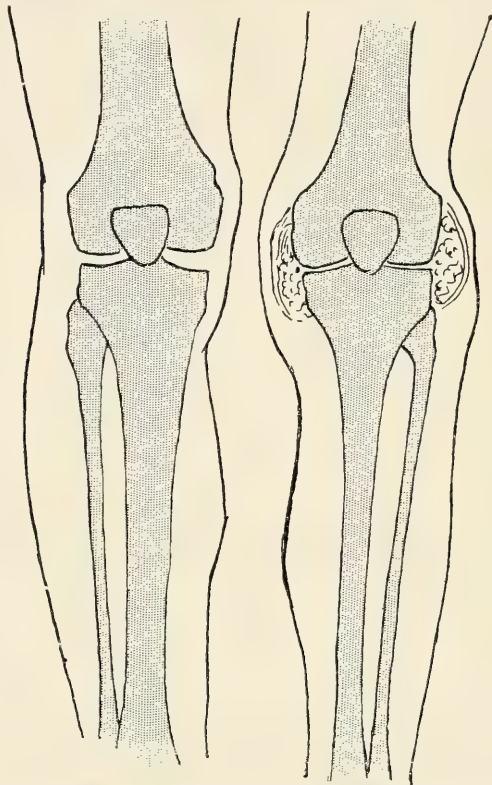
White swelling of the knee (after a radiograph). Atrophy of the skeleton on the affected side; increase in volume of the knee, proceeding from the distension of the synovial cavity by fungous masses. — Compare with fig. 1030. Other elements of diagnosis with osteo-myelitis: tuberculosis generally involves the articular extremities; osteo-myelitis nearly always the diaphysis. The onset is insidious in tuberculosis, acute in osteo-myelitis, etc.
